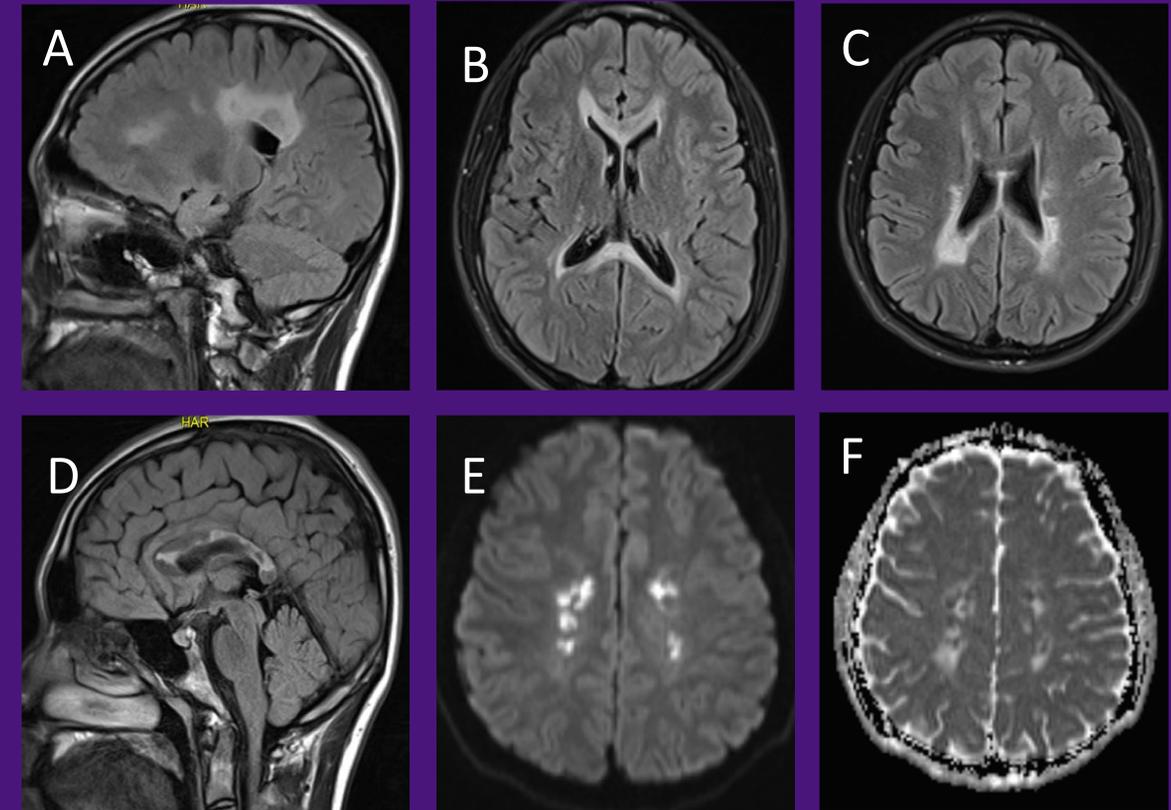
A) Sagittal FLAIR sequence show periventricular lesions with posterior predominance. B, C) Axial FLAIR sequence shows periventricular and corpus callosum lesions. D) Corpus Callosum lesions. E, F) Periventricular lesions showing diffusion restriction
